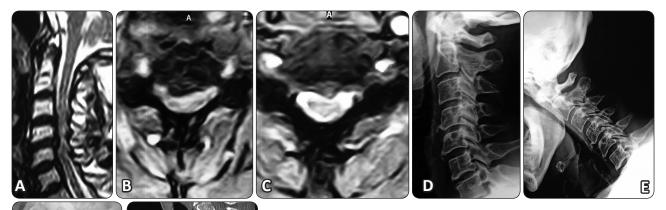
A 55 years old male presented with gait disturbance and numbness of the right UL&LL over three months duration.(a) Sagittal T2, (b) and (c) Axial T2 MRI of the cervical spine showing multilevel (C3-C7) posterior broad based disc protrusion indenting the cord associated with hypertrophied ligament flava especially at C4-5 level resulting in hourglass cord compromise and cord oedema, (d) Lateral, (e) Flexion and (f) Extension views of the cervical spine showing no signs of instability so the patient was operated by laminectomy without fusion, (g) Postoperative sagittal CT of the cervical spine showing three level laminectomy (C4-6).
